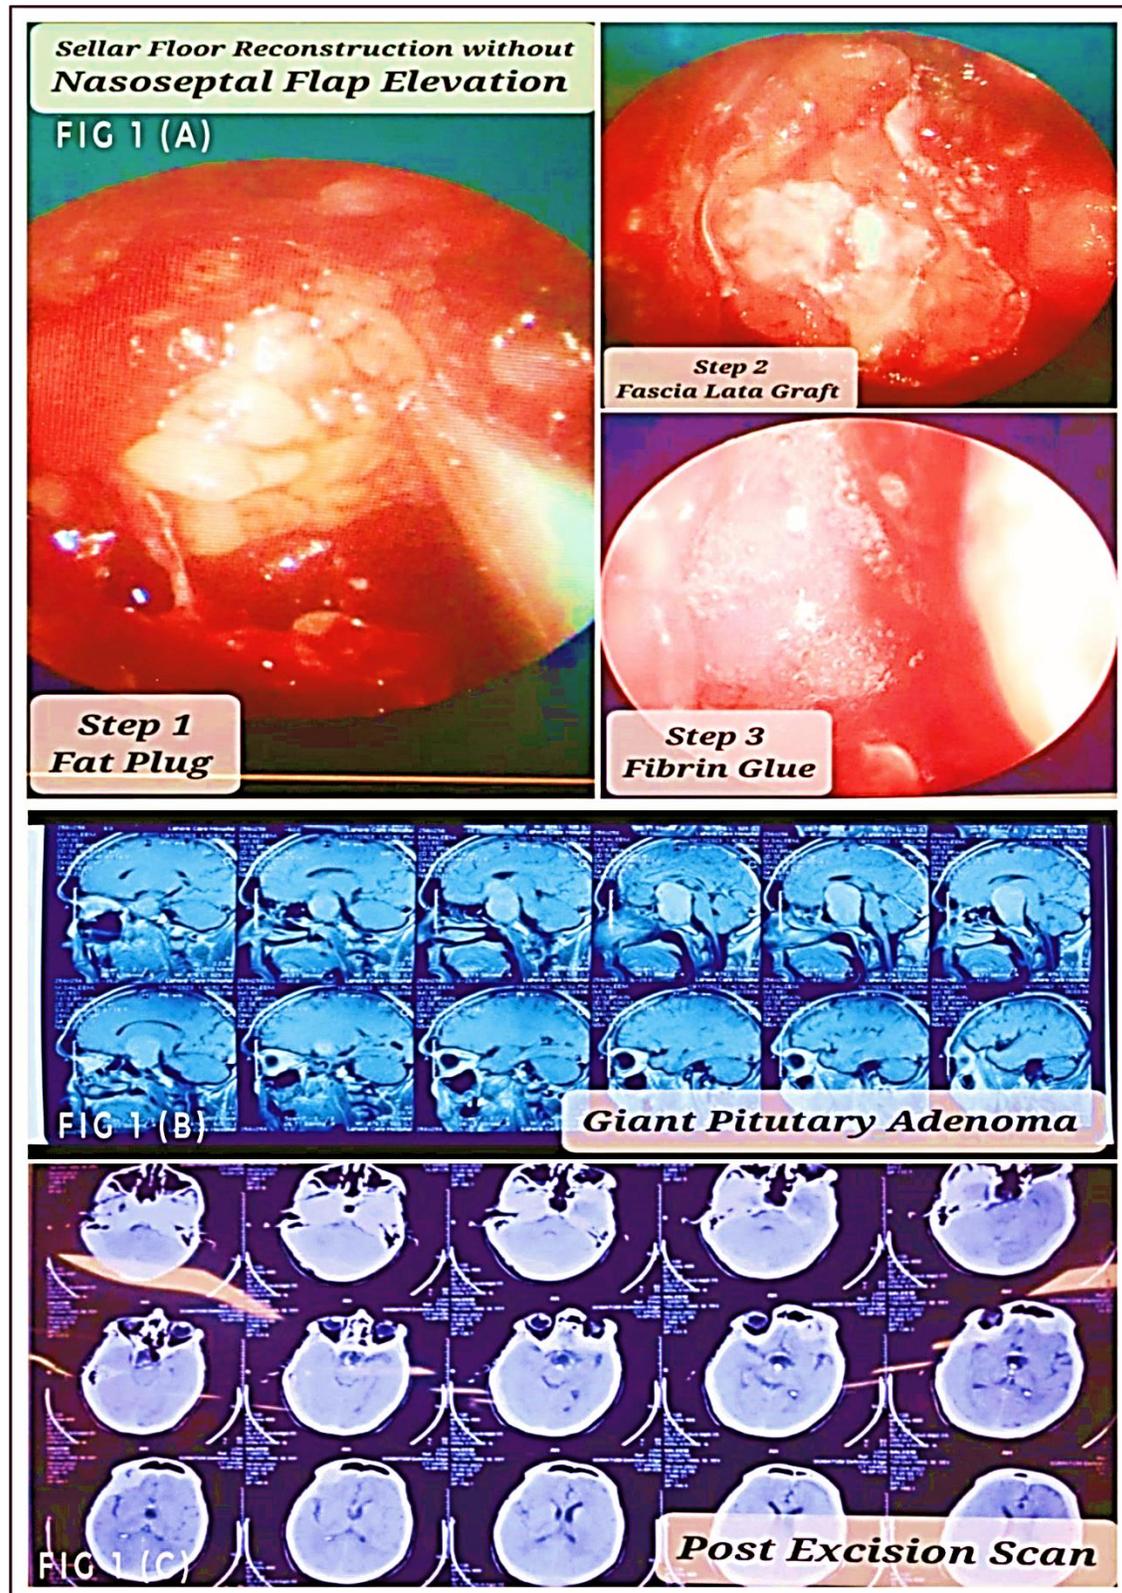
(a): Sellar Floor Reconstruction without Nasoseptal Flap Elevation after Excision of Giant Pituitary Adenoma above. Figure 1(b): MRI Brain of the same patient pre op below. Fig 1(c): Postoperative CT brain of the same patient. (Scans shared with the patient's consent).
